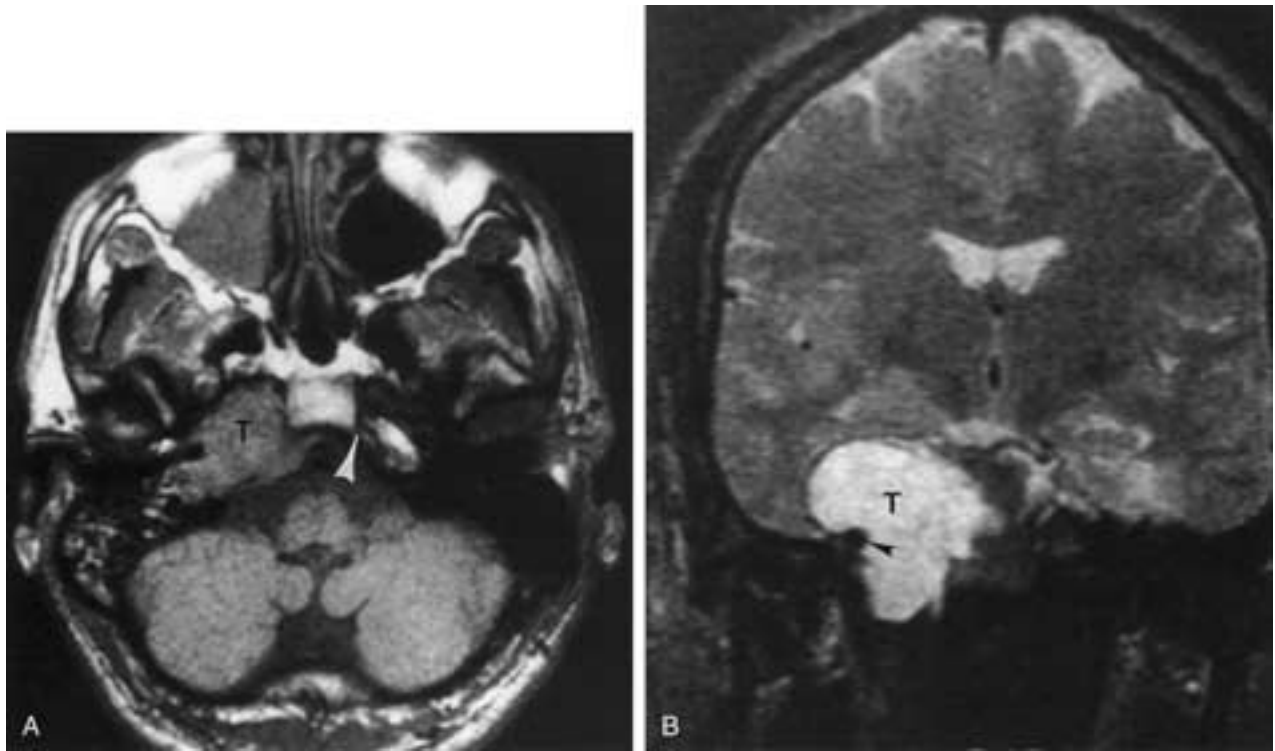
A, Chondrosarcoma of the petrooccipital synchondrosis. The tumor (*T*) shows an intermediate signal intensity on this T1-weighted image without contrast. Compare the position of this chondrosarcoma with the normal petrooccipital synchondrosis on the normal side (*arrowhead*). B, T2-weighted coronal image shows the tumor (*T*) extending inferiorly through the region of the petrooccipital synchondrosis and the foramen lacerum. The carotid artery (*arrowhead*) is pushed laterally.
